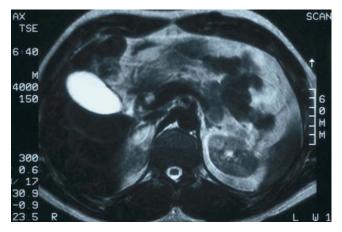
An insulinoma is demonstrated in the head of the pancreas by T_2 -weighted magnetic resonance imaging.
